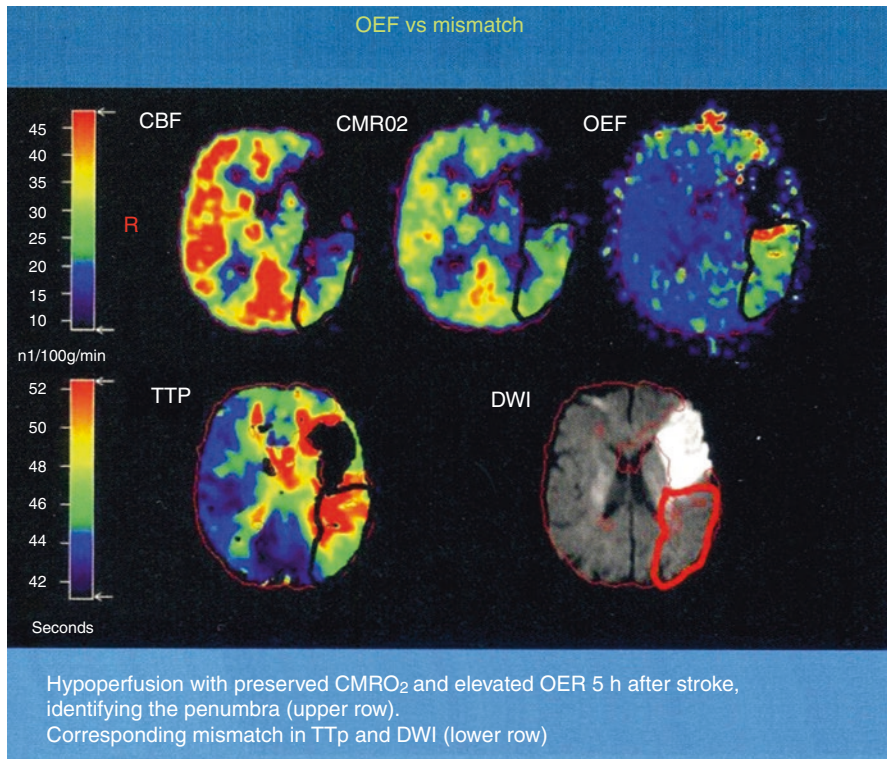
Coregistered images of multitracer PET (upper row) and PW/DW-MRI (lower row) in a patient with right-sided hemiparesis and expressive aphasia 5 h after symptom onset. The penumbra is characterized by hypoperfusion (CBF), preserved $CMRO_2$, and elevated OEF. These findings correspond grossly to the mismatch between DWI hyperintensity and a TTP delay of 4 s compared with the unaffected hemisphere
